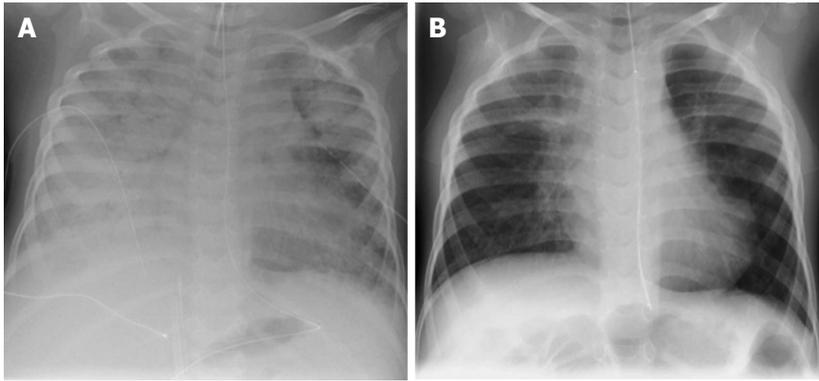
Anterior-posterior chest radiograph. A: Postintubation anterior-posterior chest radiograph of a 4 years old boy before Extracorporeal membrane oxygenator (ECMO) support with acute respiratory distress syndrome caused by proven novel 2009 H1N1 influenza virus; B: Anterior-posterior chest radiograph of the same patients after successful veno-atrial ECMO weaning and successful decanulation.
